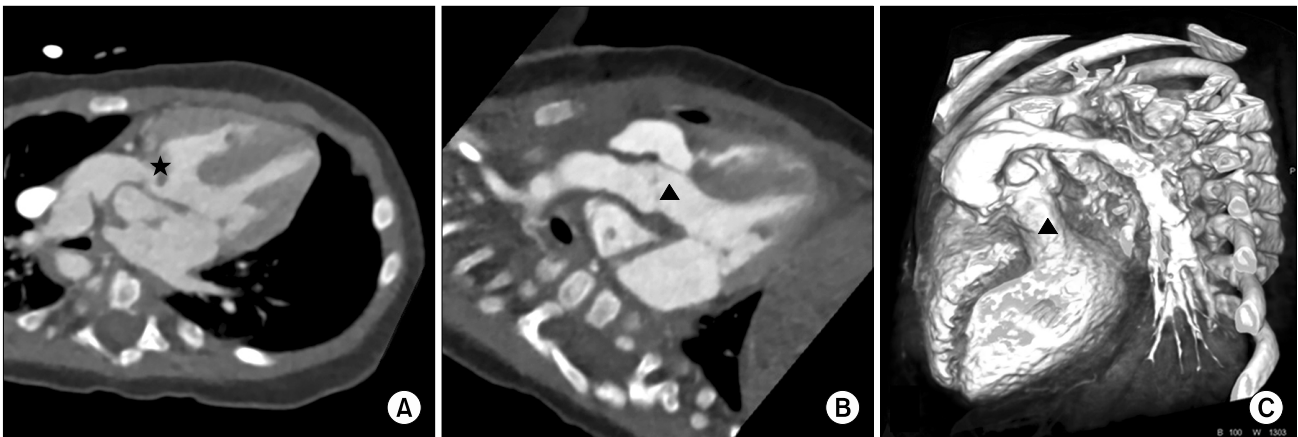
Case 1: double outlet right ventricle with ventricular septal defect and pulmonary stenosis. (A) Preoperative CT indicating a severely posterior deviated conal septum (★). (B, C) Postoperative CT indicating a widened left ventricle outflow tract (▲). CT, computed tomography.
